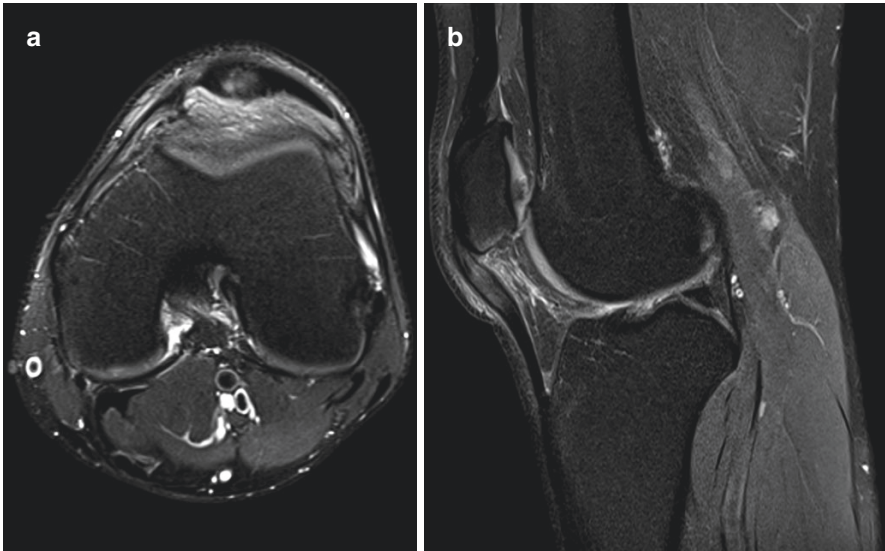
MR images [PD tse fs tra (a) and sag (b)] in case of refractory patellar tendinopathy showing increased diameter at the proximal origin of the patellar tendon with hyperintense signal in the tendon as well as in the infrapatellar fat pad and adjacent distal patellar bone
